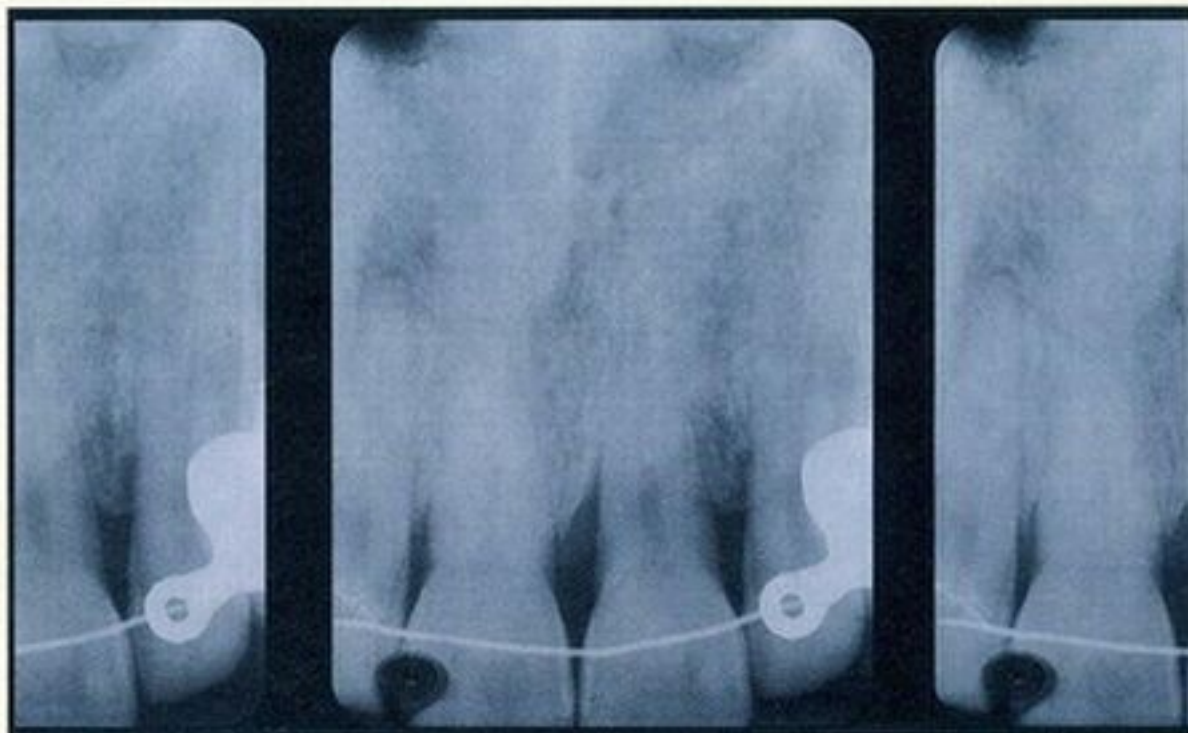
Eighteen-month posttreatment radiograph of the maxillary central incisor region.
